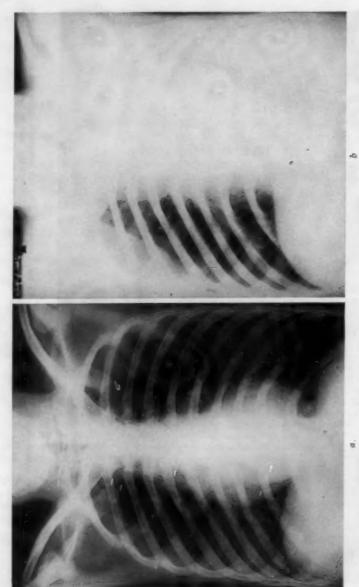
Chest x-ray examination demonstrates slight shift of the heart to the right, narrowing of the right intercostal spaces and elevation of the right diaphragm consistent with right pulmonary atelectasis. b. Four days later, atelectasis of the left lung.
